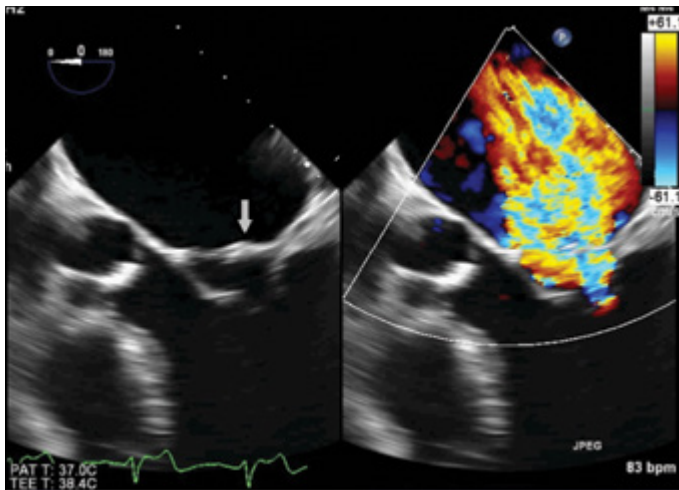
Transesophageal echocardiography demonstrates the mitral annuloplasty ring and severe mitral regurgitation from the middle segments of both leaflets (A2 and P2 segments) in the central 5C view
